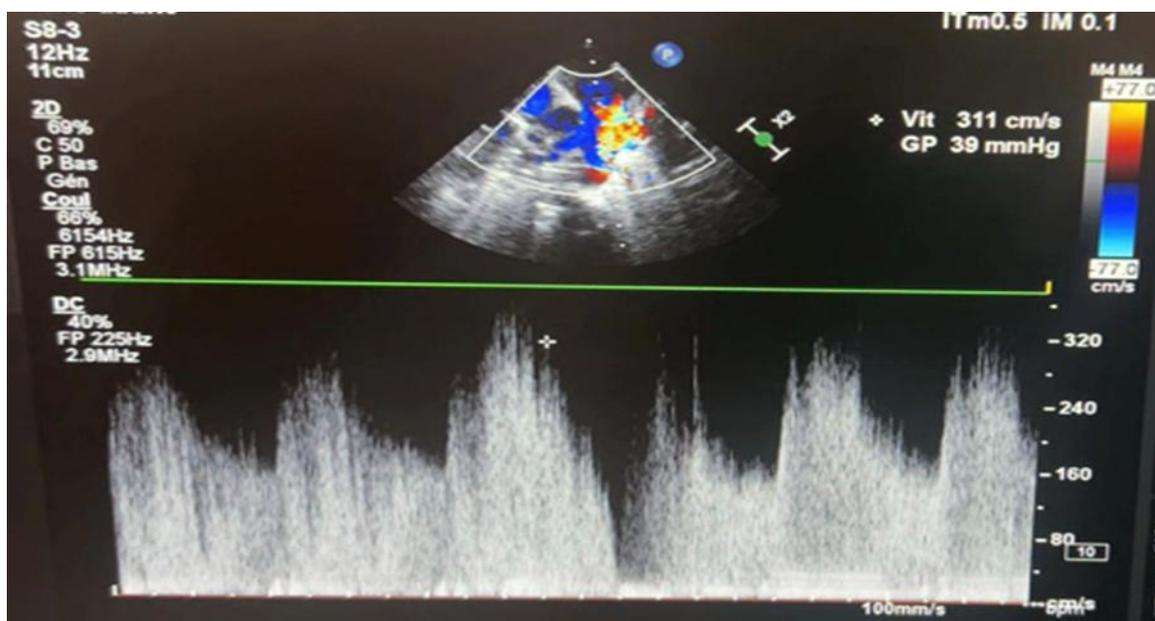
Flow from patent ductus arteriosus in continuous Doppler.
